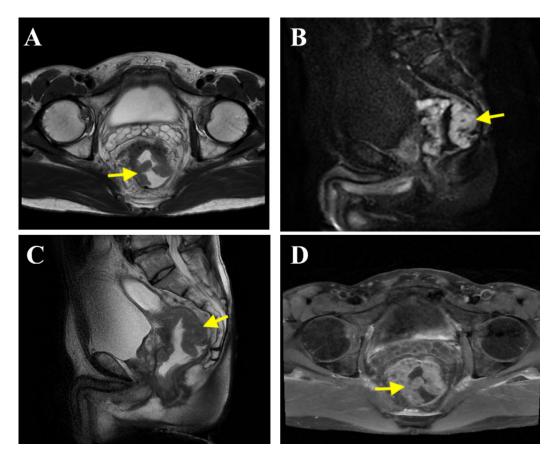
Rectal cancer (arrow) was assessed by MRI. A, Axial T2-weighted (T2W); (B) Sagittal diffusion-weighted imaging (DWI); (C) Sagittal T2W; (D) Axial T1W with contrast enhancement.
